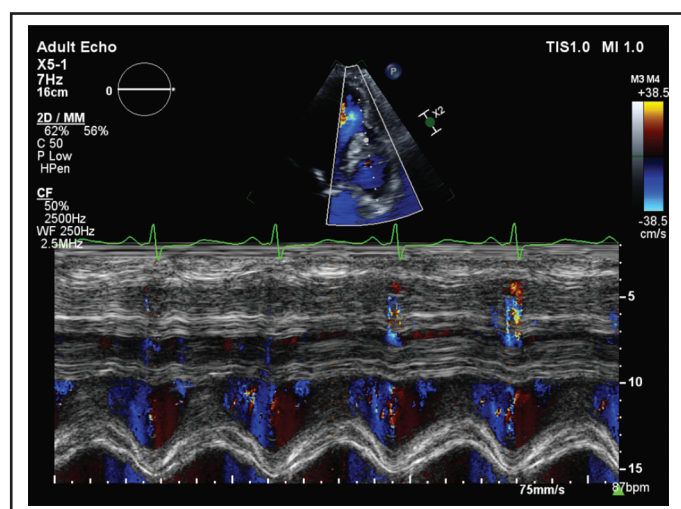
Muscular diverticulum with M-mode. M-mode imaging modality with color shows blood flow through a muscular diverticulum in an apical 3-chamber window. This modality allows the sonographer to appreciate the synchronous mechanical activity with the contractile function of the LV.⁶ M-mode allows the sonographer to see how the diverticulum maintains its shape and size during cardiac cycles.
